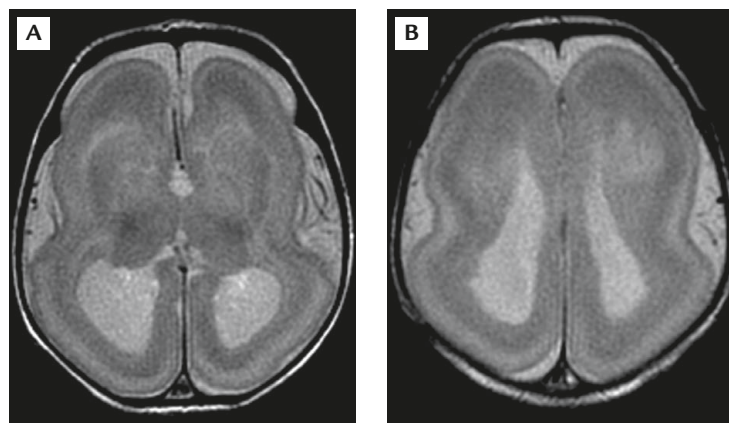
(A, B) Magnetic resonance imaging of the brain at birth shows agyria/pachygyria, a figure-of-eight appearance of the brain, a wide and shallow sylvian fissure, dilation of the lateral ventricles, and agenesis of the corpus callosum.
